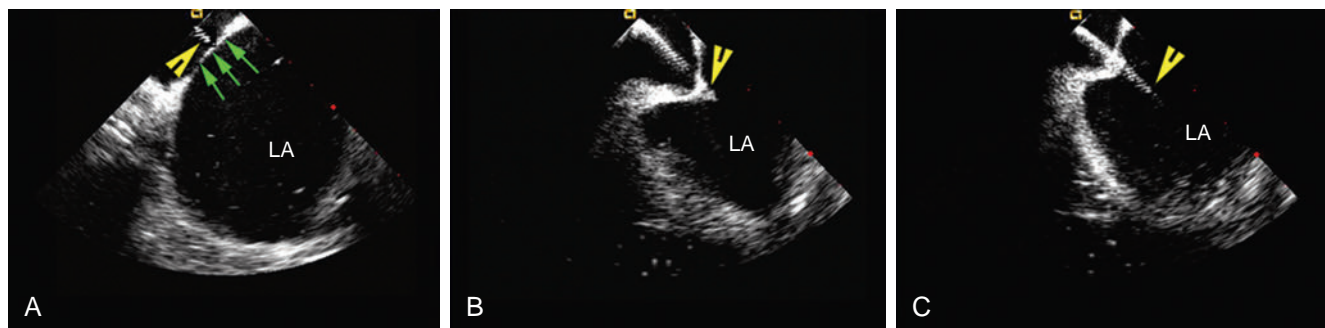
Phased-Array Intracardiac Echocardiography (ICE)-Guided Transseptal Puncture. (A) These ICE images, with the transducer placed in the right atrium (RA), show a transseptal dilator tip (yellow arrow-head) lying against the interatrial septum (green arrows). (B) With further advancement of the dilator, ICE demonstrates tenting of the interatrial septum at the fossa ovalis. (C) Advancement of the transseptal needle is then performed, with the needle tip visualized in the left atrium (LA), and tenting of the interatrial septum is lost.
